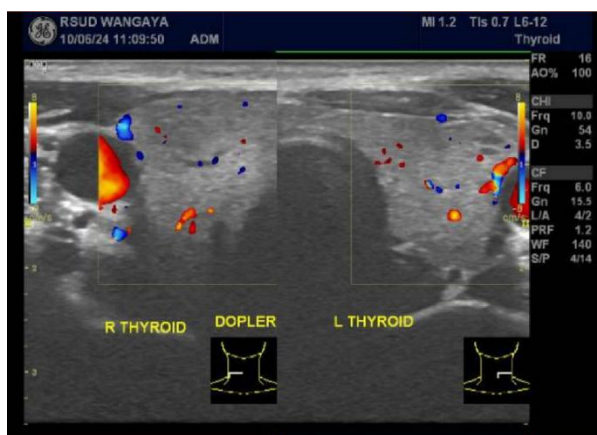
Thyroid ultrasound of the Patient
